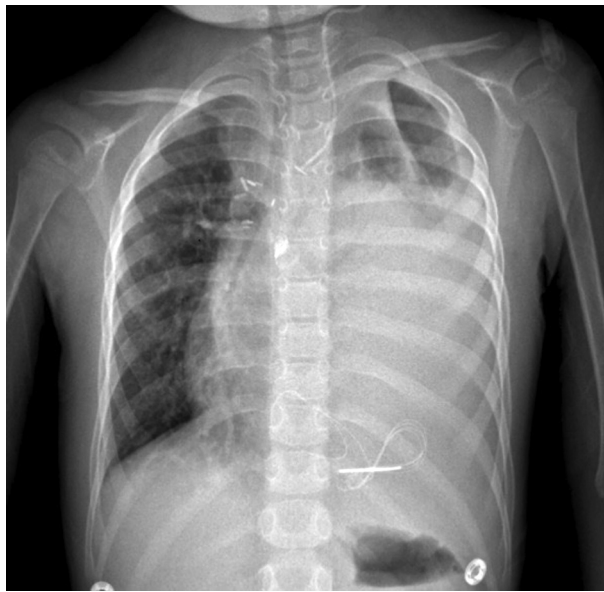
Chest radiograph demonstrating pleural effusion (chyllothorax).
